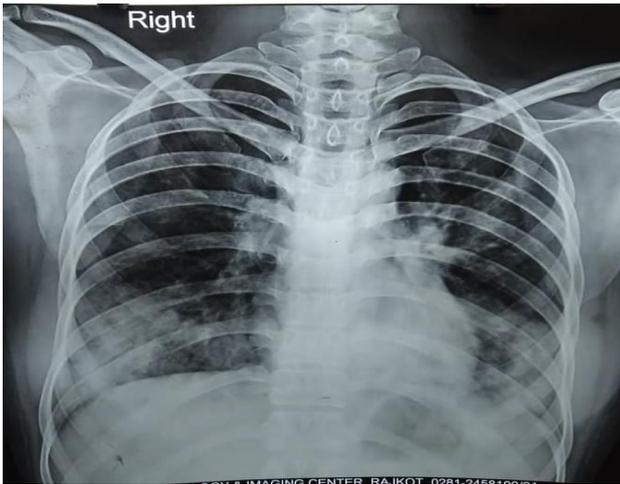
Chest X-ray of ILD in a patient of systemic sclerosis.
